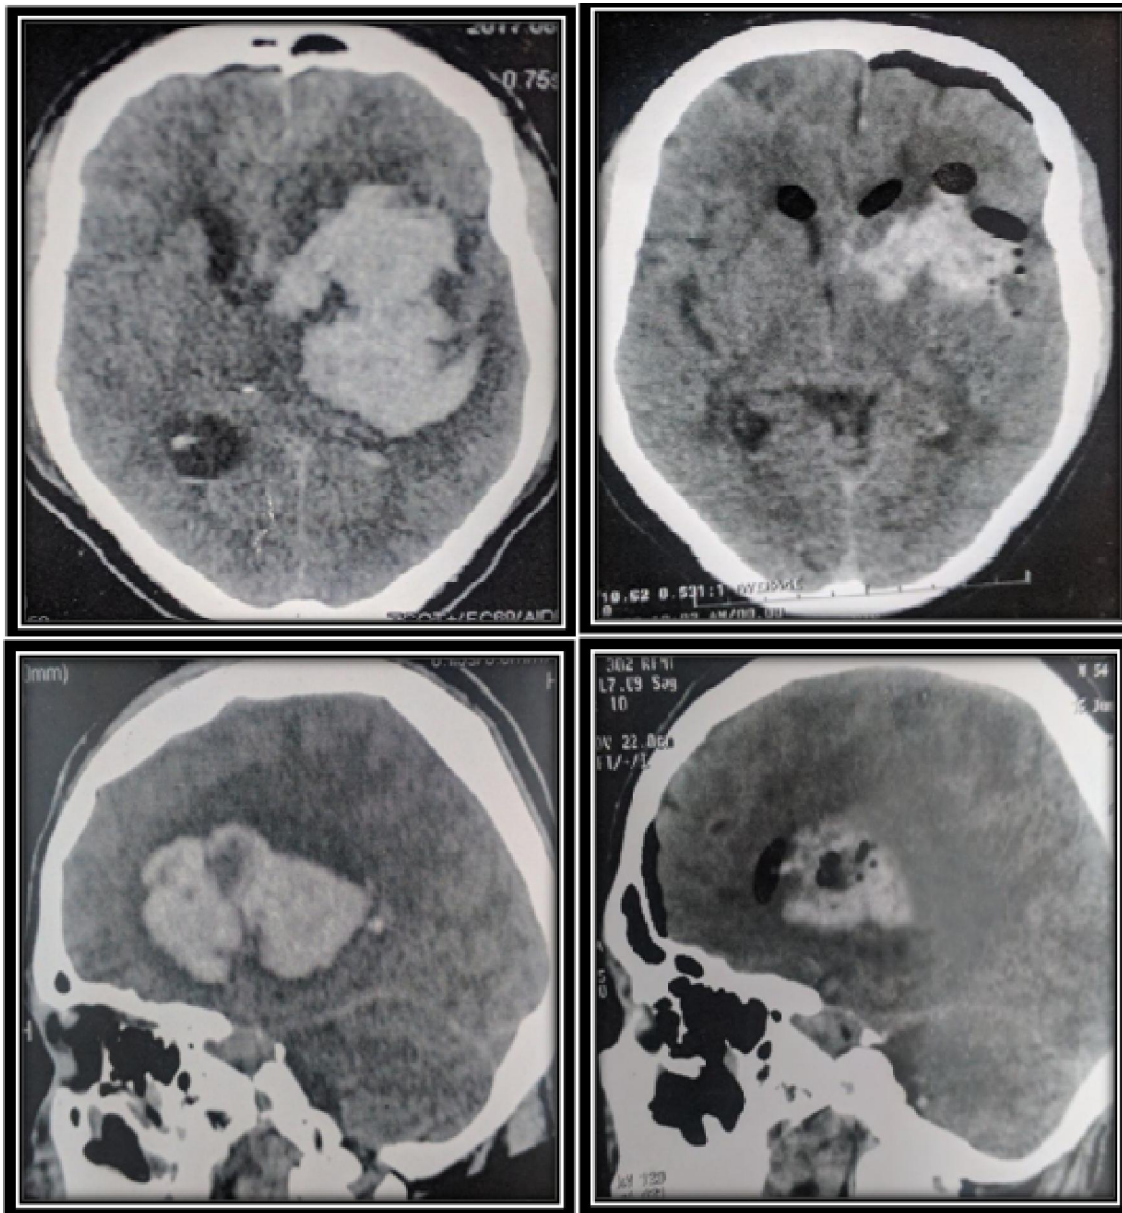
showing comparison between preoperative CT brain (axial, sagittal) of a male 55y. patient has left 55cc hematoma with GCS 7 and postoperative CT brain (axial, sagittal) of the same patient with surgical entry point at kocher's point. Evacuation rate was 83.6 %.
